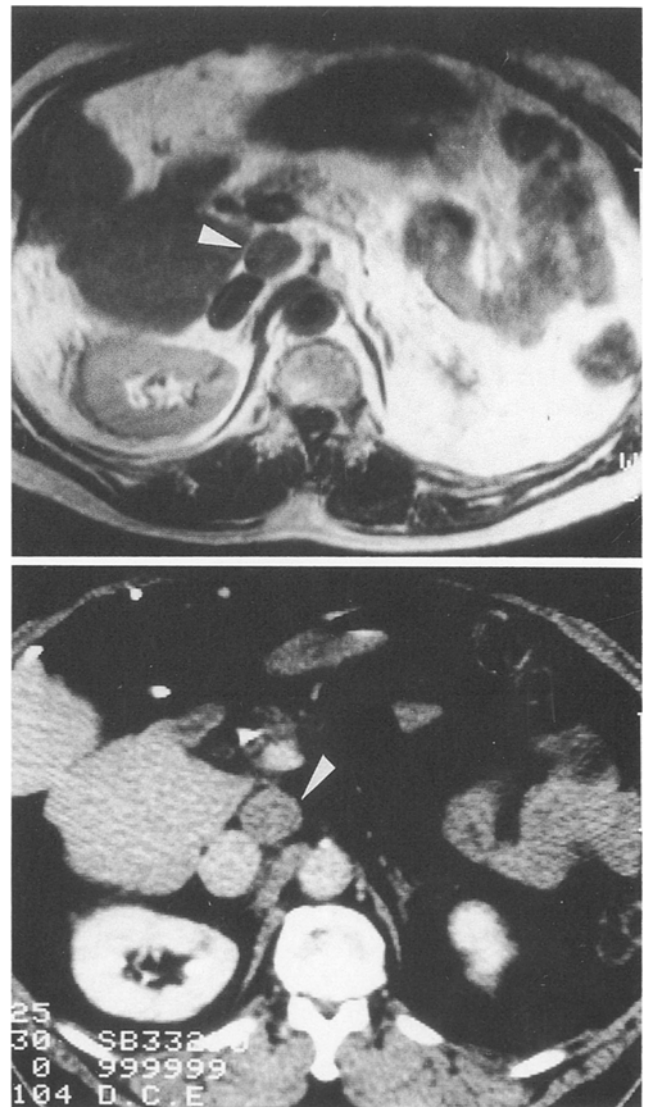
CT (*top*) and T1-weighted magnetic resonance imaging (MRI) (*bottom*) findings of case 4. Swelling of the posterior pancreaticoduodenal lymph node can be seen
